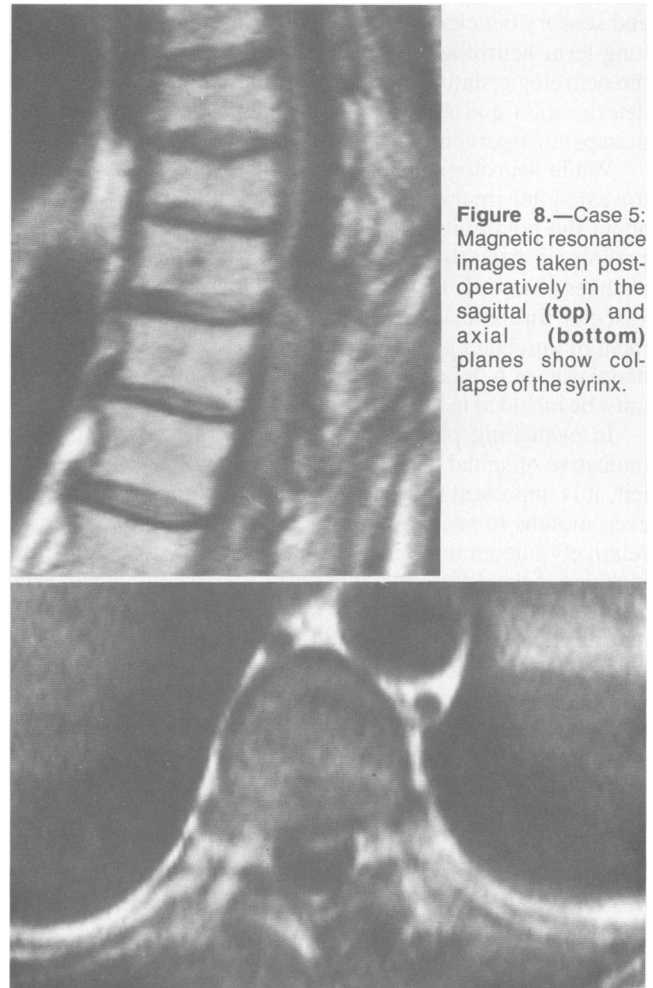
Case 5: Magnetic resonance images taken post-operatively in the sagittal (top) and axial (bottom) planes show collapse of the syrinx.
